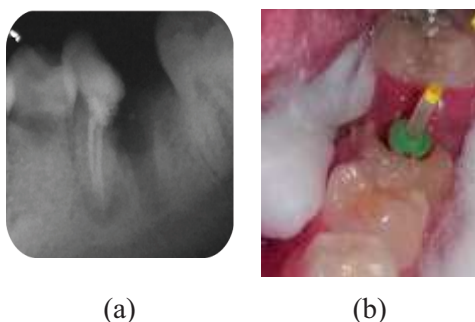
(a) Radiograph view after the distal root was extracted; (b) Clinical view when inserting the fiber post.
